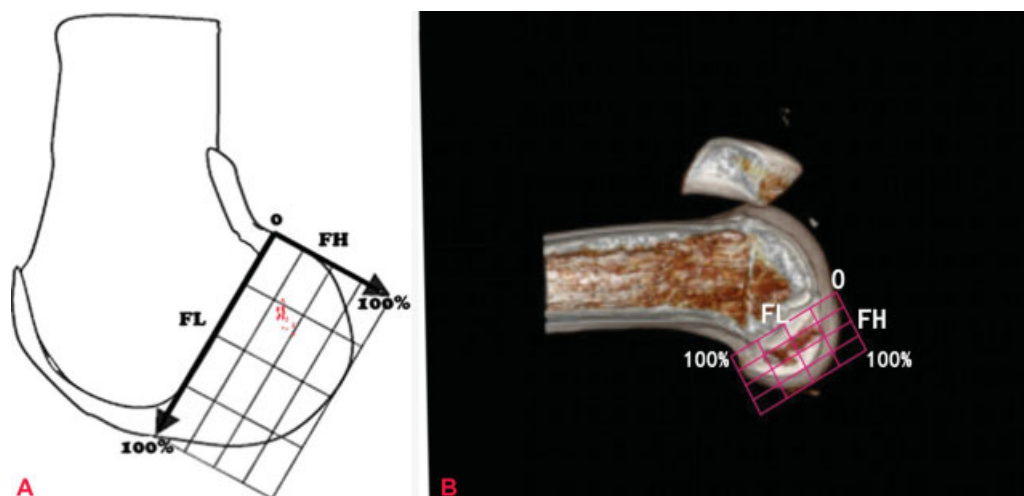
(A) Femoral length (FL) represents the distance from the most posterior contour of the lateral femoral condyle parallel to the intercondylar notch roof and femoral height (FH) represents the perpendicular distance from the intercondylar notch roof to the deepest borders of the condyle. Femoral tunnel position on three-dimensional (3D) computed tomography (CT) is measured according the quadrant method. (B) Anatomic femoral tunnel placement. (Redrawn from Xu et al⁴²).
